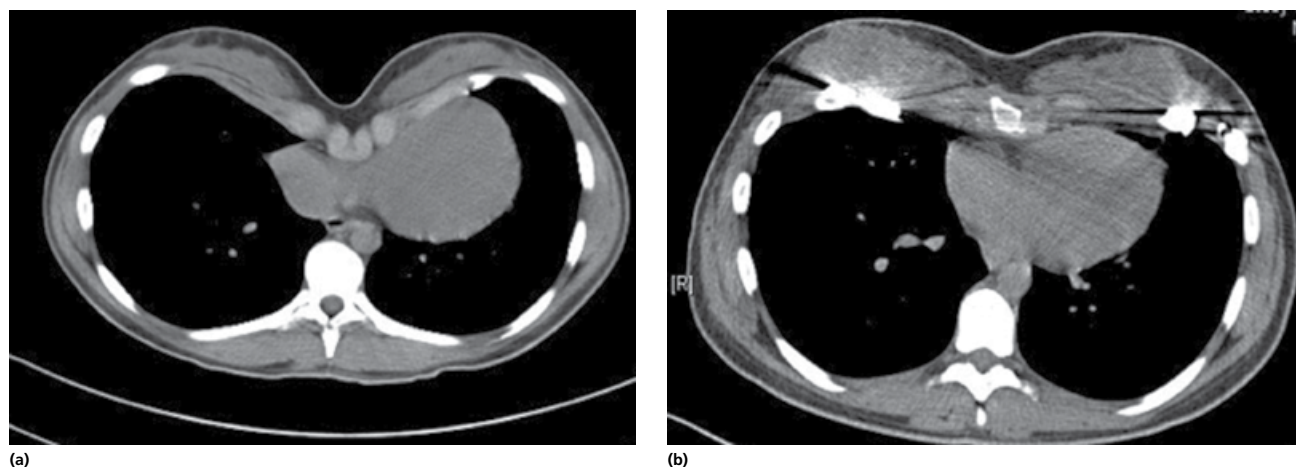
Transverse section of a CT scan of a patient with pectus excavatum, before (a) and after (b) Nuss correction. Note the cardiac compression seen before correction.
